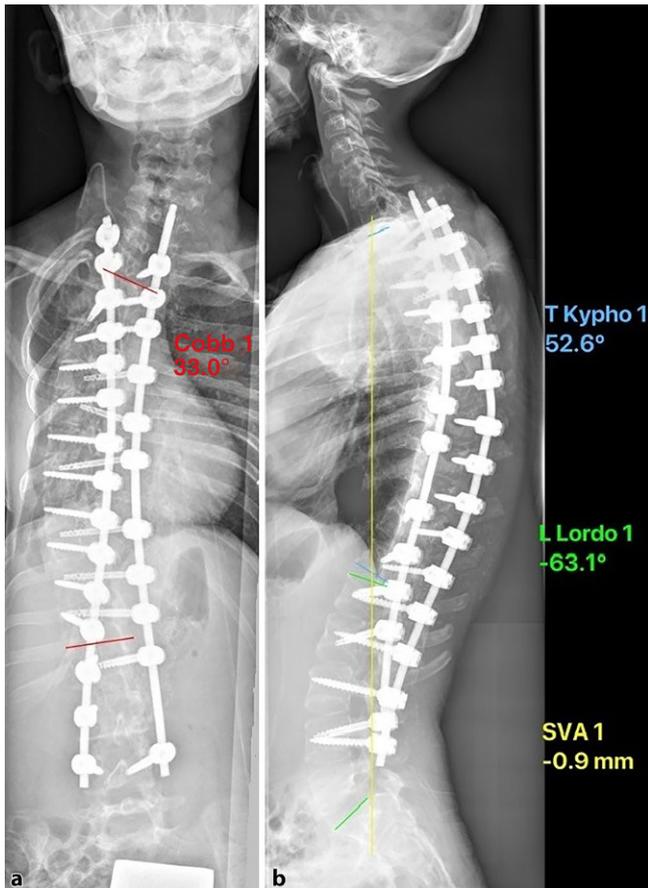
◀ Postoperative radiographs of the patient in an anteroposterior (a) and lateral (b) view of the vertebral column after posterior fusion. *T Kypho* thoracic kyphosis, *L Lordo* lumbar lordosis, *SVA* sagittal vertical axis
